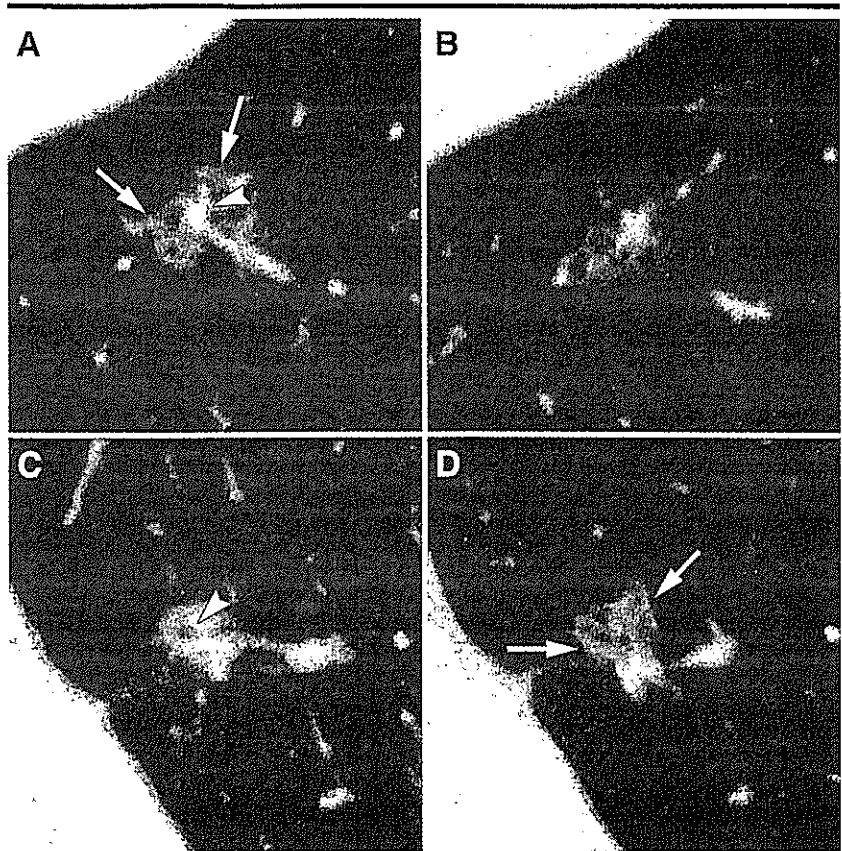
Transverse thin-section CT images. *A, B*, Images show a malignant mixed GGO lesion (adenocarcinoma) with irregular margins. The nodule shows both GGO in the periphery (arrows) and a high-attenuation zone (arrowhead) in the center. *C, D*, Images show a benign mixed GGO lesion (nodular fibrosis) with irregular margins. In *C*, a small air collection (arrowhead) is seen in the nodule. In *D*, the nodule (arrows) is seen on another section.
